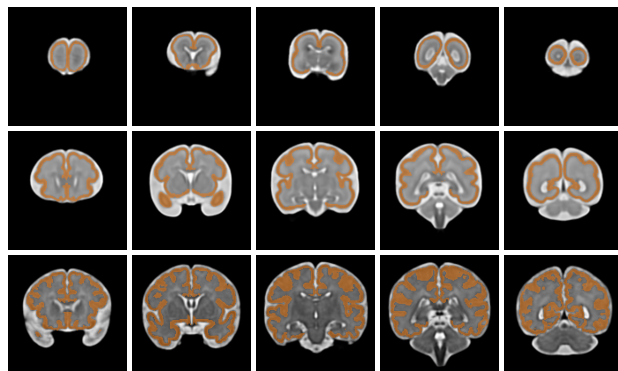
Examples of cortical plate segmentations in the STA dataset. The rows contain sagittal slices of the same MRI, for gestational week 21 (top), 30 (middle) and 38 (bottom).
